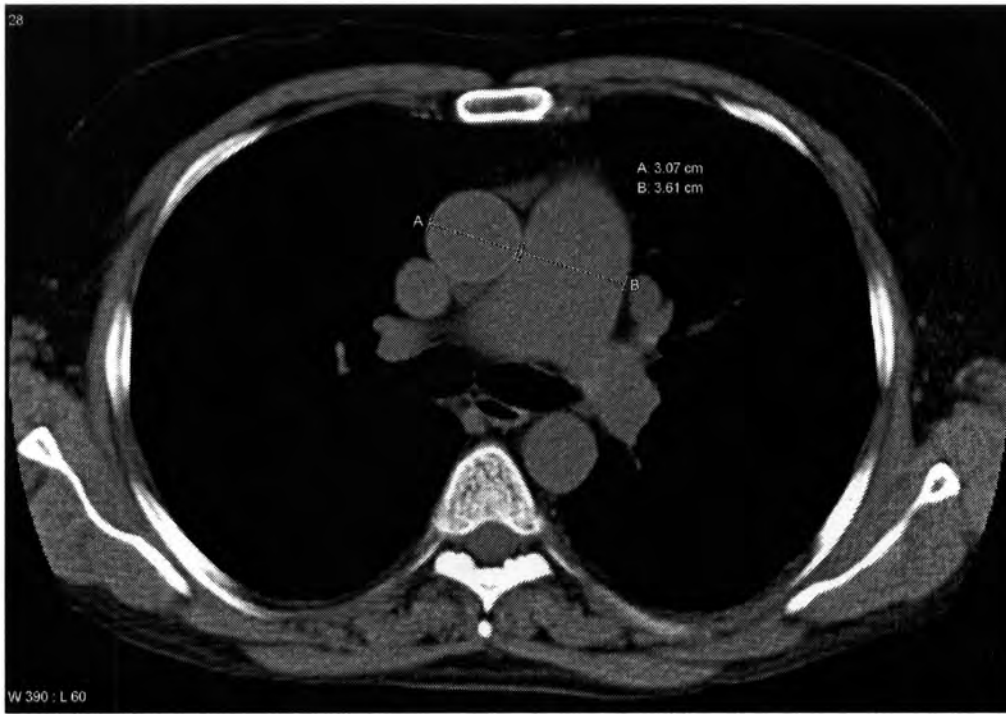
Demonstration of MPAD Measurement on Axial CT Image
